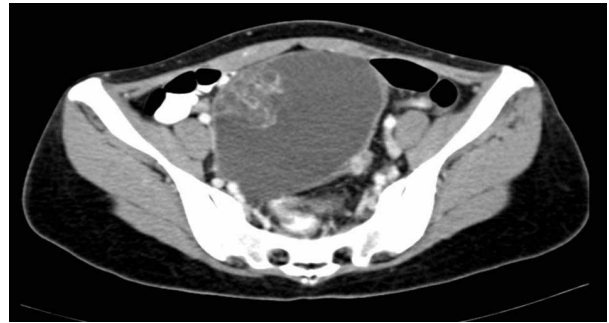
CT pelvis showing the left sided teratoma in Patient 2
